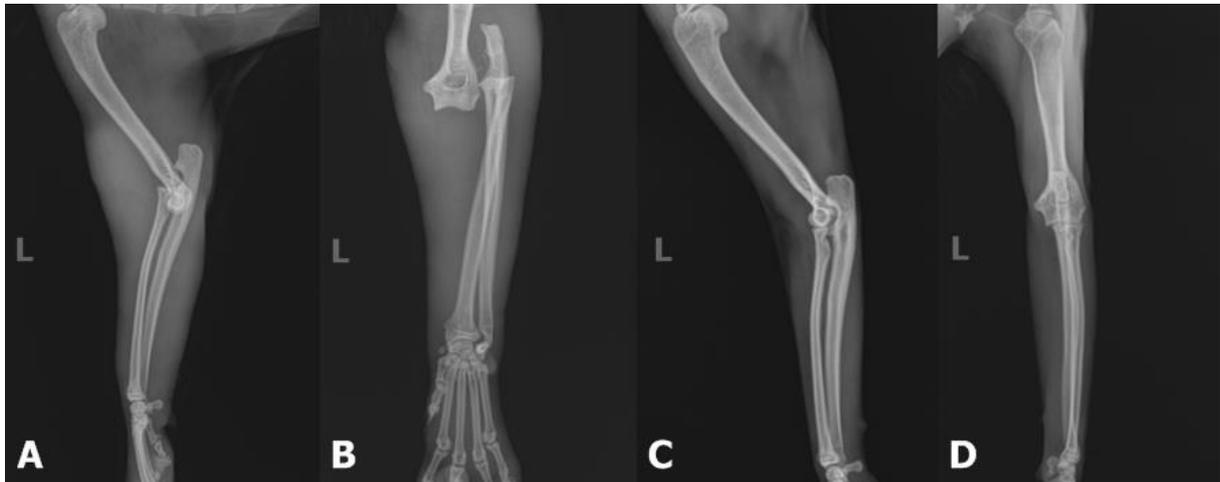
Preoperative (A,B) and postoperative 3rd week (C,D) radiographs of the case 1.
